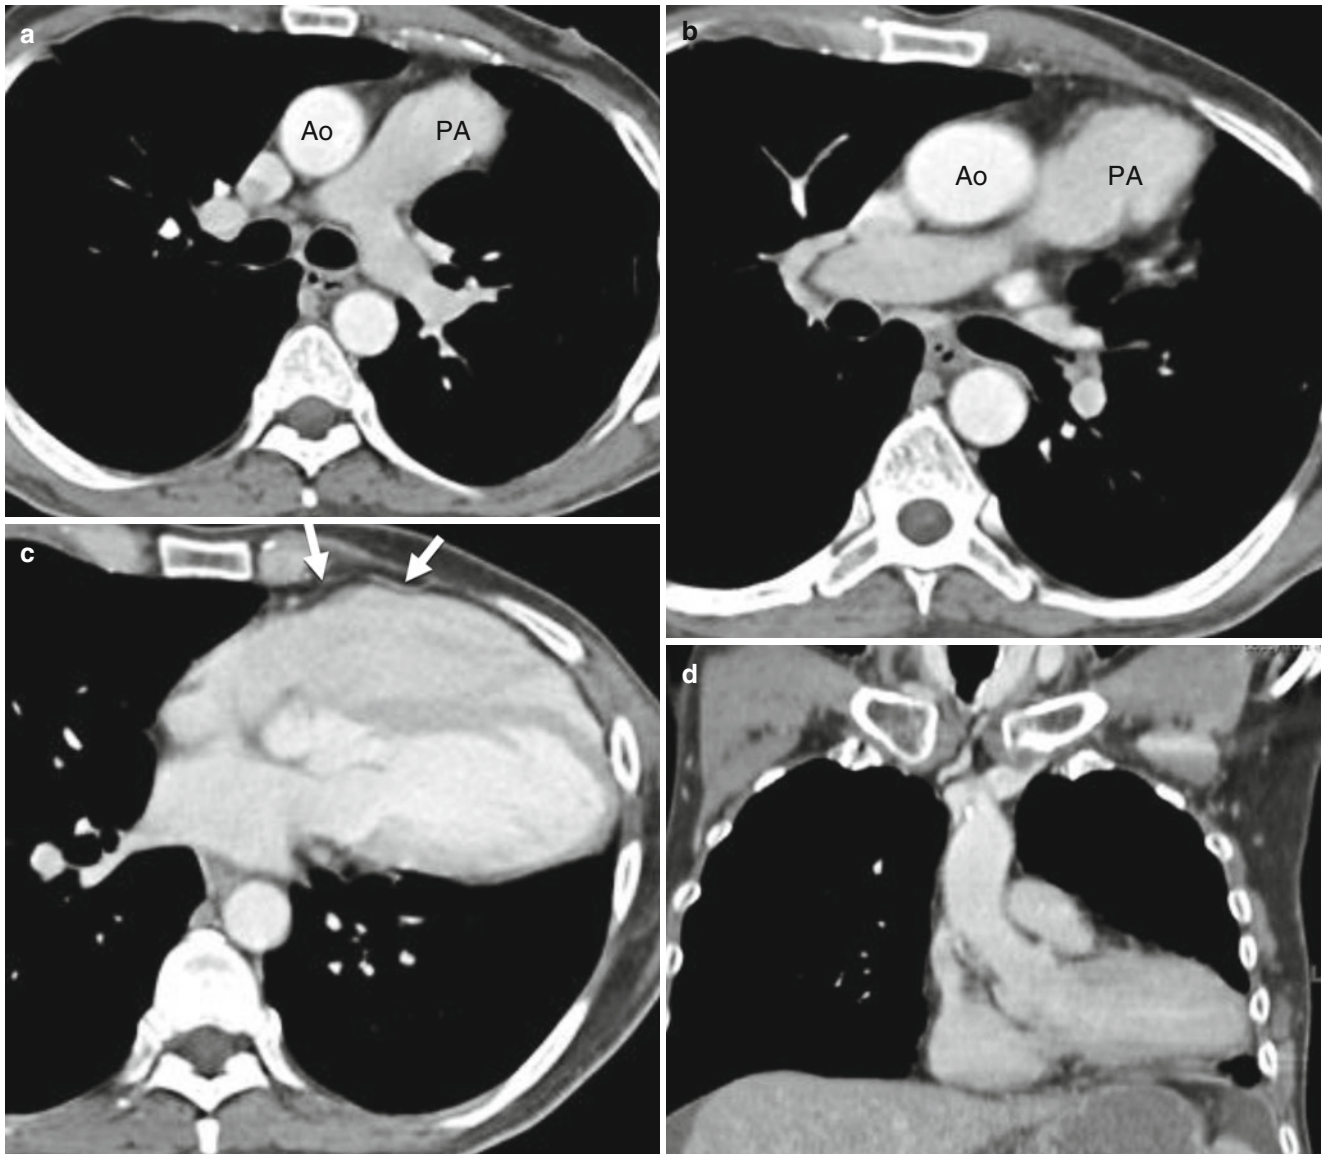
Partial absence of the pericardium. An example of a 54-year-old man with known tricuspid insufficiency and who underwent a computed tomography (CT) angiogram for evaluation of an abnormal chest radiograph. Panels (a) and (b) are axial CT images showing the main pulmonary artery (PA) extending far beyond the mediastinal margins
